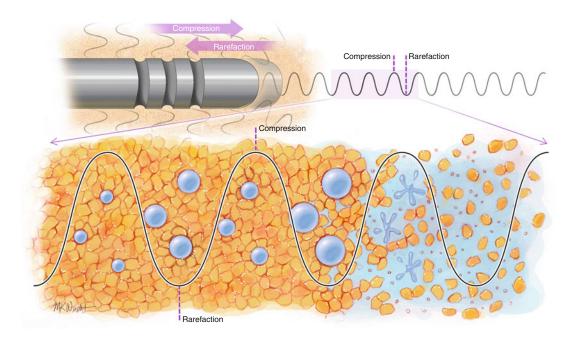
The cavitation effect. The VASER<sup>®</sup> probes vibrate at ultrasonic frequencies creating compressive and rarefactive forces around the grooved tip. Cavitation
